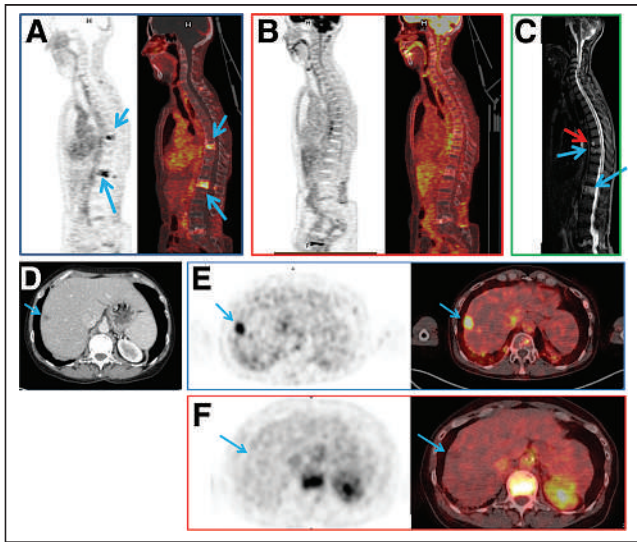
(A–C) In patient 1, pretargeted immuno-PET with TF2 and ^{68}Ga -IMP288 peptide images show 2 vertebral metastases (L1 and T9, arrows) (A), ^{18}F -FDG PET discloses no vertebral abnormalities (B), and vertebral MRI confirms both lesions (blue arrows) and discloses another lesion (red arrow) at T8 (C). (D–F) In patient 2, CT shows suspected liver lesion (D), and pretargeted immuno-PET with TF2 and ^{68}Ga -IMP288 peptide reveals high uptake by liver lesion (arrow) (E), which was not seen by ^{18}F -FDG PET (F). (Reprinted from (21).)
